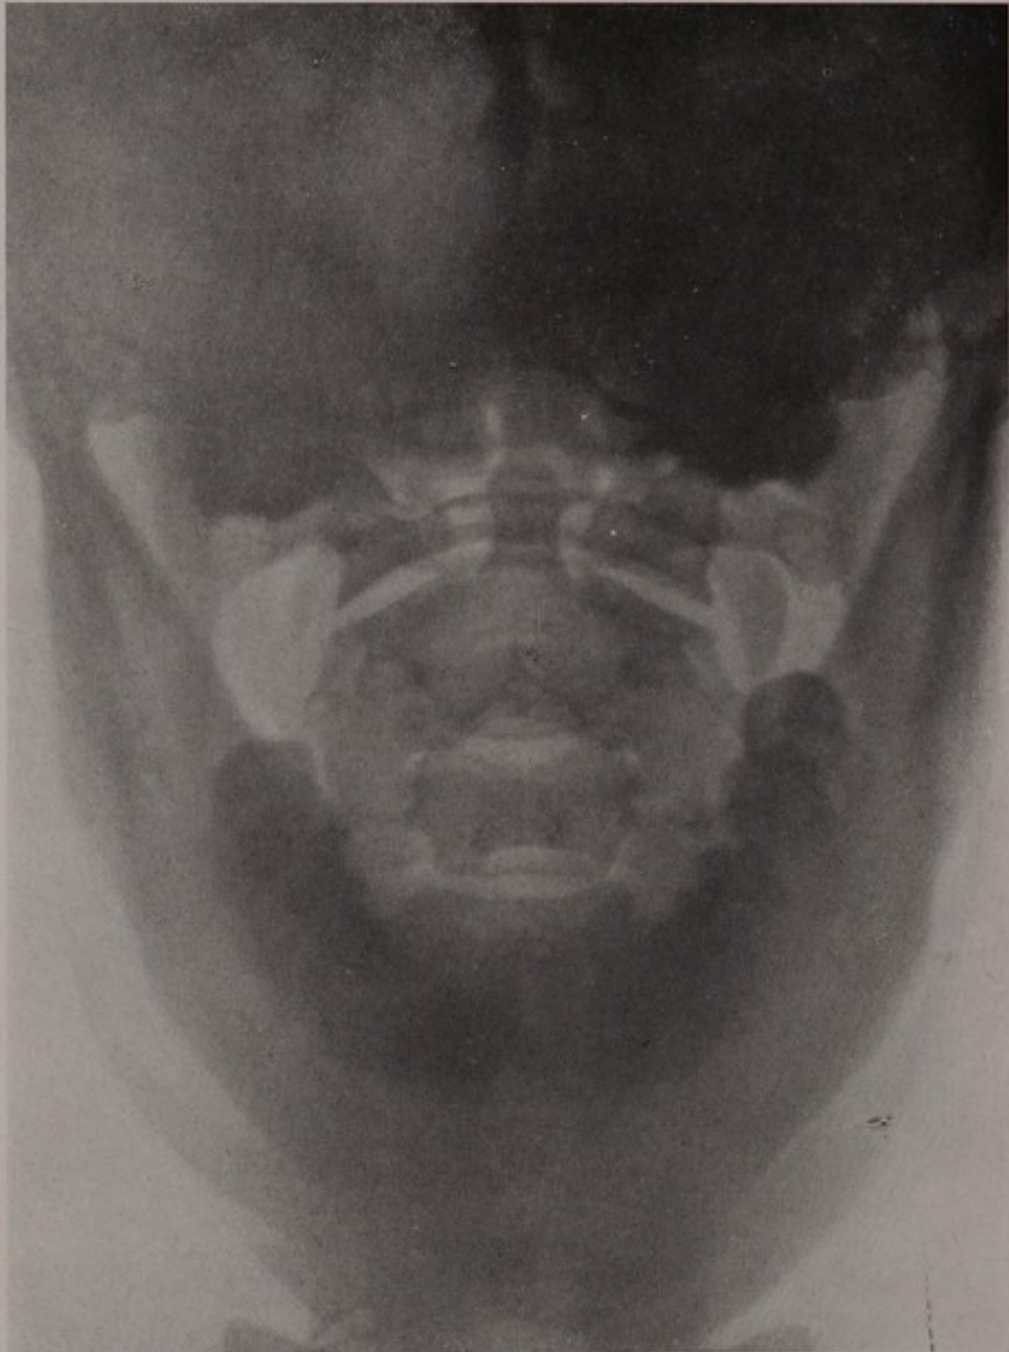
b*.—X-ray of normal cervical vertebræ, the atlas and axis.
